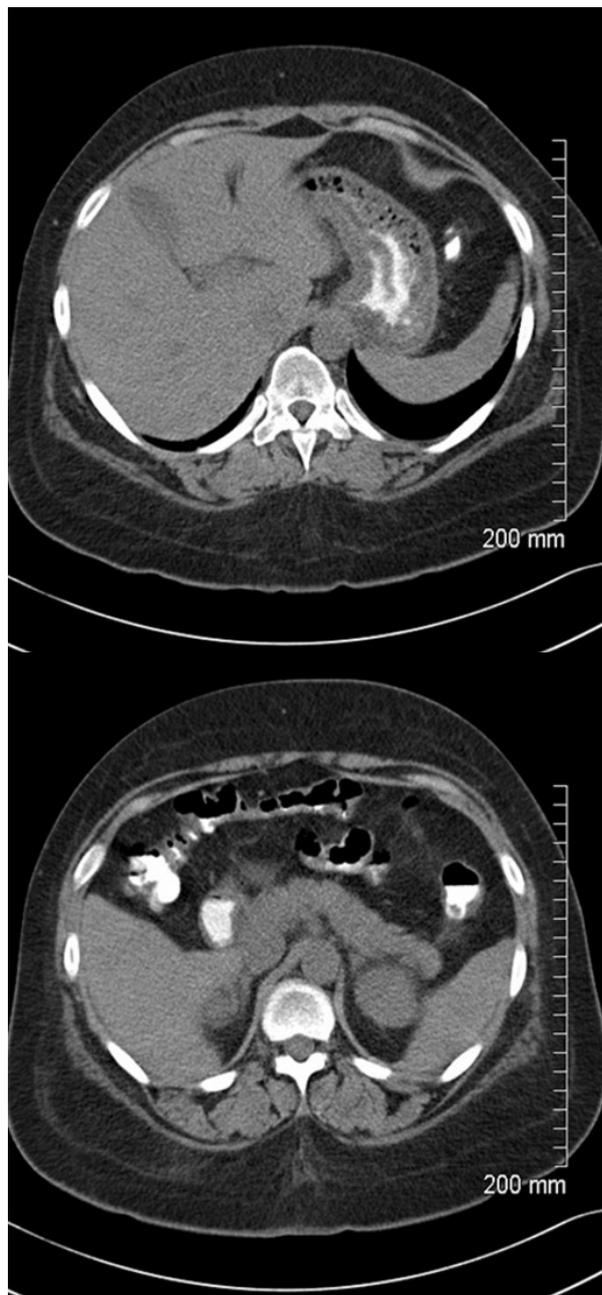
CT scan showing normal pancreas with no fluid accumulation in the pelvis, and normal stomach wall.
